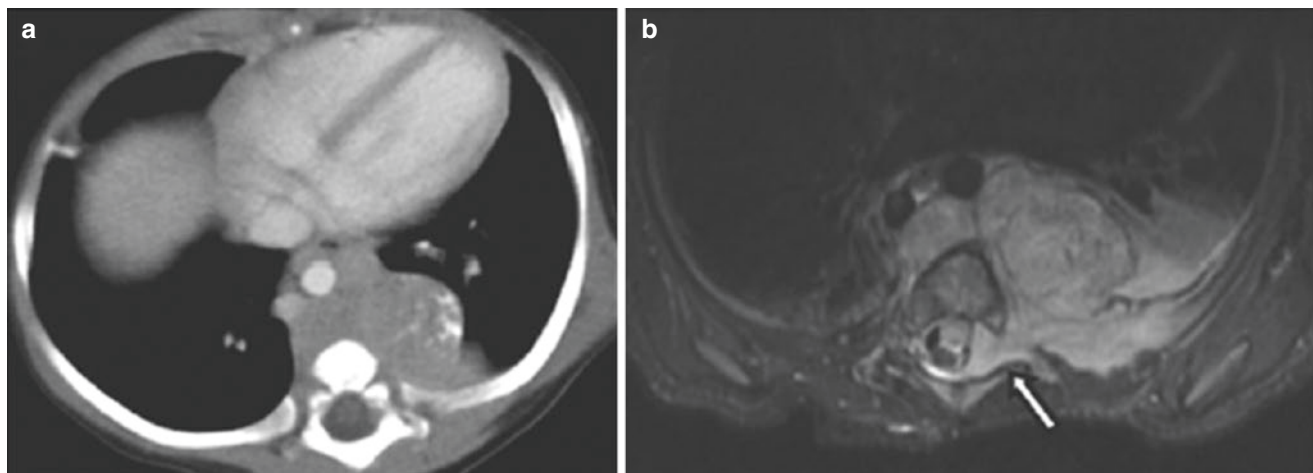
A 3-month-old boy who presented with vomiting. After abdominal ultrasound failed to reveal the cause of his symptoms, a CT was performed after an abnormal CXR. (a) Enhanced axial CT image demonstrates a large left posterior mediastinal mass with regions of calcification.
